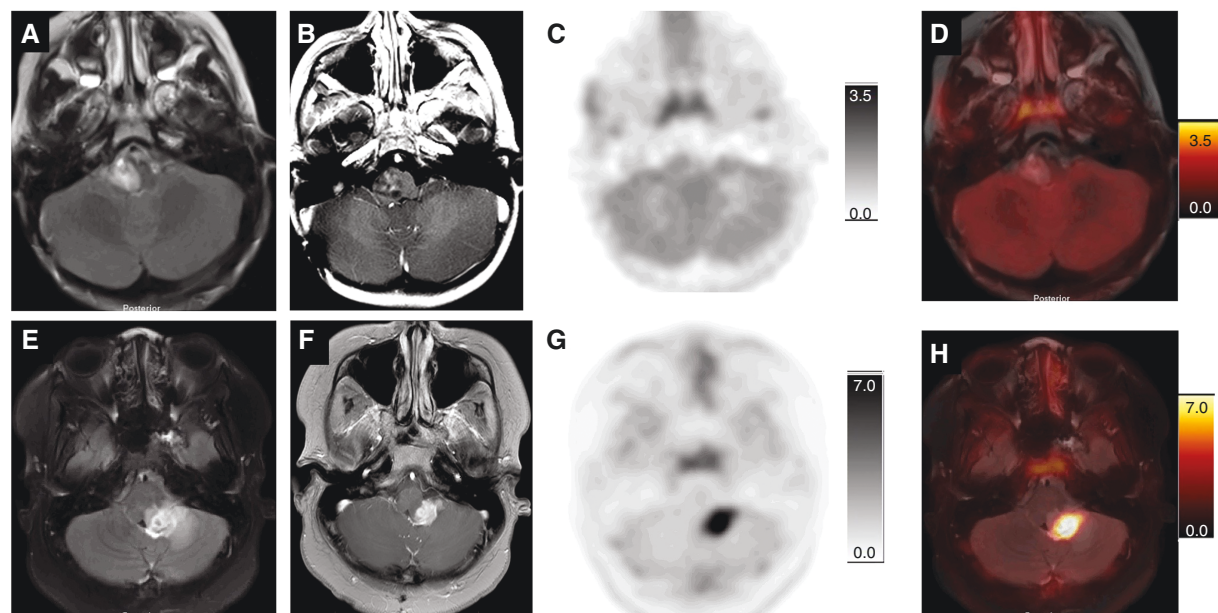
Pilomyxoid astrocytoma. (A-D) A) Axial FLAIR image through the posterior fossa demonstrated a T2 hyperintense tumor involving the right side of the medulla that demonstrated patchy enhancement on post-contrast T1 weighted image (B). The Attenuation corrected [¹¹C]-MET-PET image (C) demonstrated barely any uptake of the tracer over the area of abnormality, as shown on the overlay image (D) with a TBR_{max} of 1.83. Ganglioglioma. (E-H; E) Axial FLAIR image through the posterior fossa demonstrated a T2 hyperintense tumor involving the inferior aspect of the left middle cerebellar peduncle, dorsal aspect of the inferior pons (anteriorly), and cerebellum (posteriorly) with nodular enhancement on post-contrast T1 weighted image (F). The Attenuation corrected [¹¹C]-MET-PET image (G) demonstrated intense uptake of the tracer over the area of abnormality, as shown on the overlay image (H) with a TBR_{max} of 6.84.
